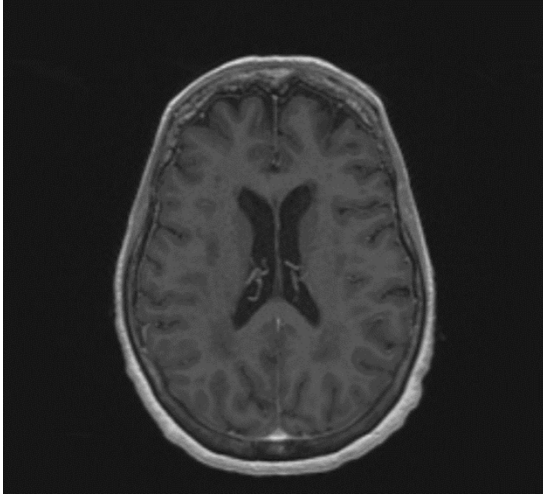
T1 post-contrast MRI Brain without abnormal findings or pathology.
